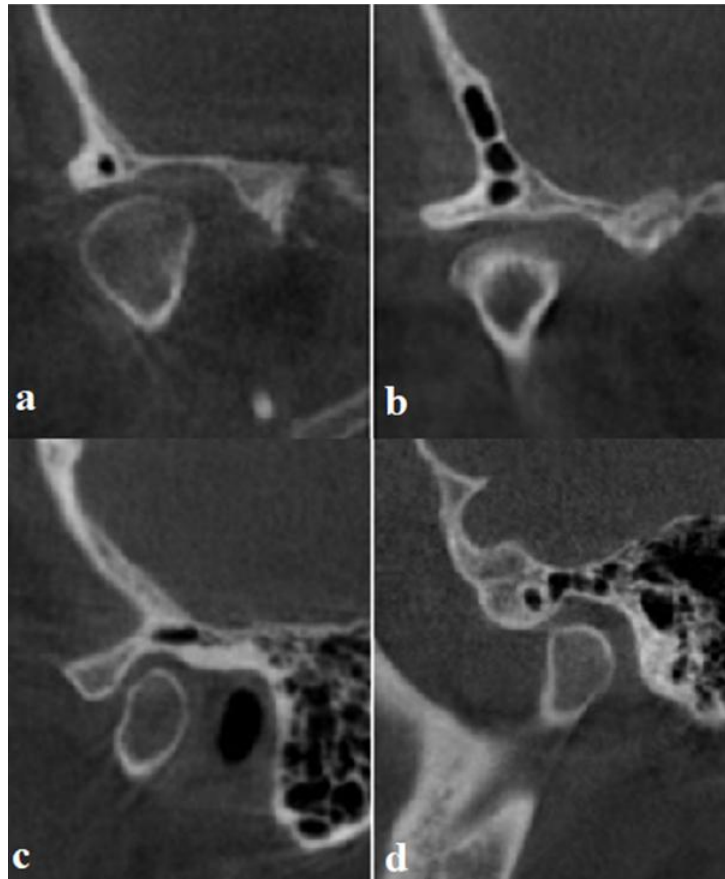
In CBCT sagittal sections; unilocular (a) / multilocular (b) PGF image and in CBCT coronal sections; unilocular (c) / multilocular (d) PGF image.
